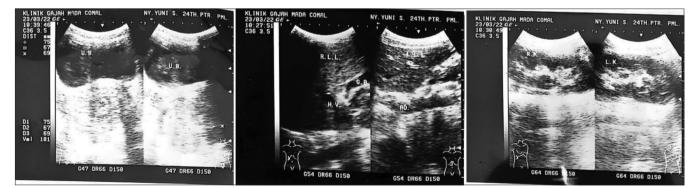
Ultrasonography result Source: Personal document
